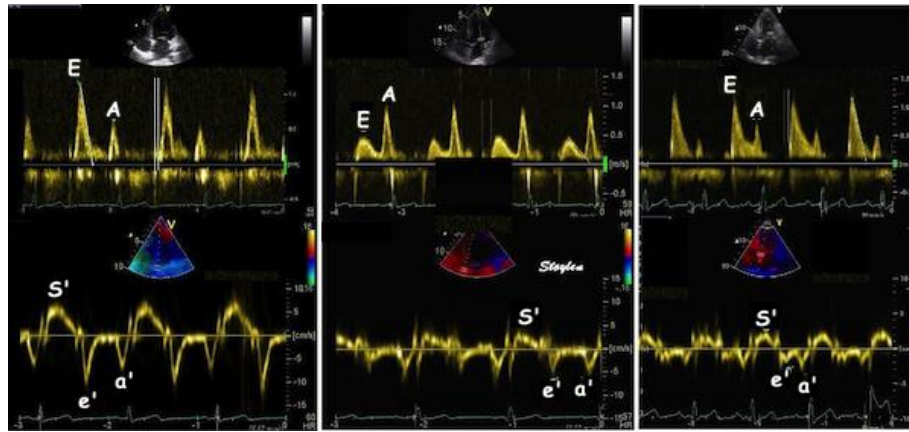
Tissue Doppler imaging of the E/A and E/e' ratio.
